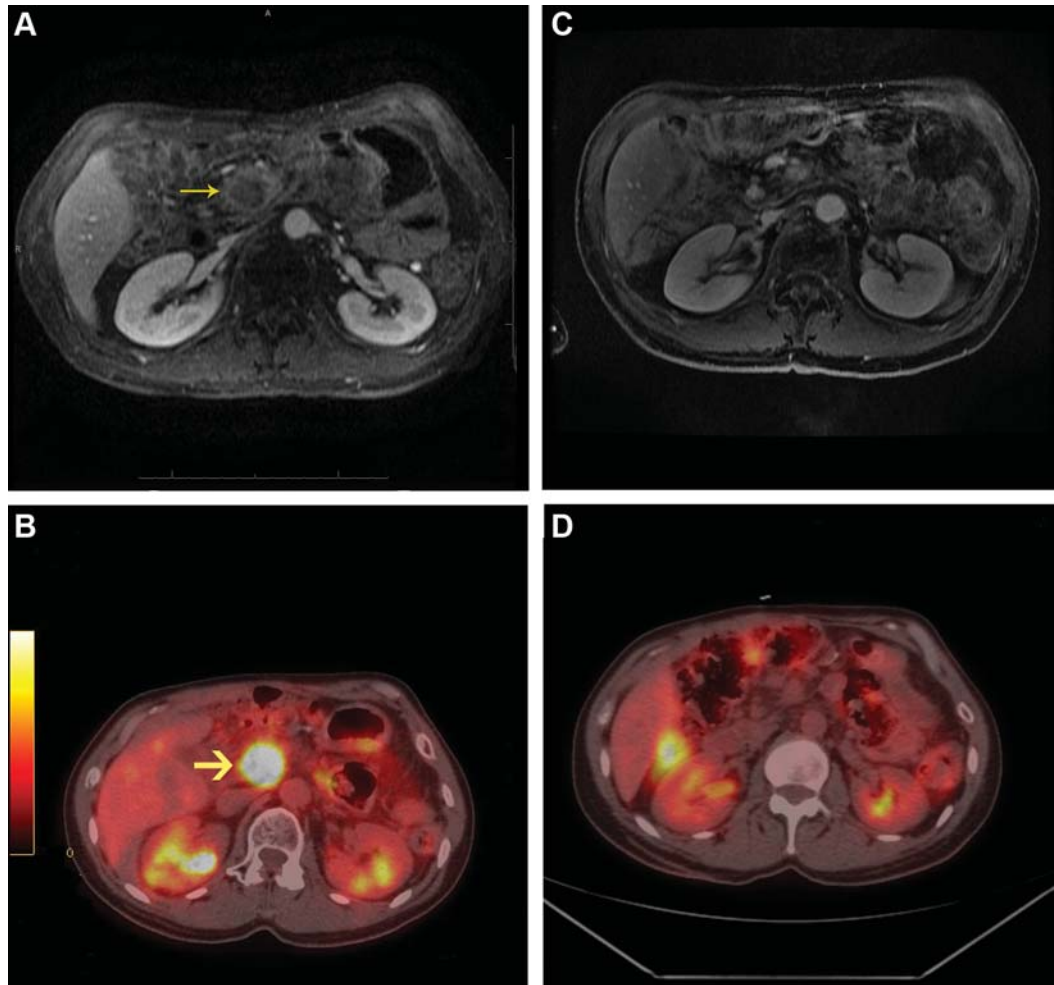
A: Pre-treatment MRI demonstrating a mass at the pancreatic bed (arrow). B: Pre-treatment PET scan demonstrating a mass at the pancreatic bed (arrow). C: Post-treatment MRI demonstrating marked improvement at the pancreatic bed (circle). D: Post-treatment PET scan demonstrating resolution of PET activity (circle).
